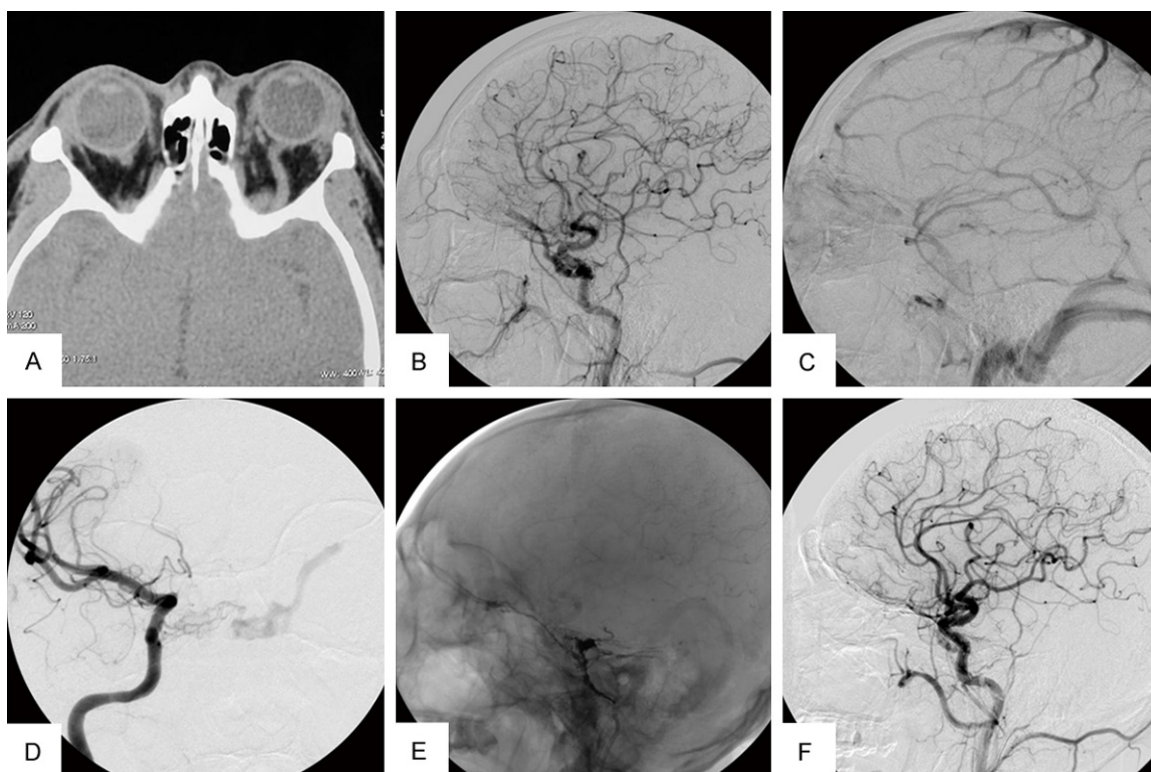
A. Computed tomographic scan of patient 6 shows the enlargement of the left SOV (arrowhead); B and C. Pre-embolization: Lateral projection of left CCA angiography arterial phase shows retrograde filling of abnormally dilated the left SOV and the venous phase shows the IPS is not opacified; D. Pre-embolization: Frontal angiography of right ICA arterial phase also shows retrograde filling of the left SOV in abnormal dilation (arrowhead); E and F. Angiogram obtained after the injection of Onyx demonstrates the existence of dilated the left SOV (arrowhead).
